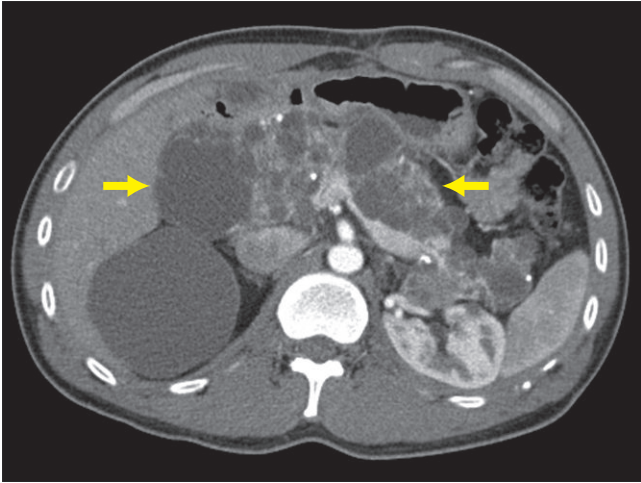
CT scan demonstrating multiple cysts within the pancreas (arrows) as well as upper pole right renal cyst. Other scans demonstrated a solid right renal mass.
